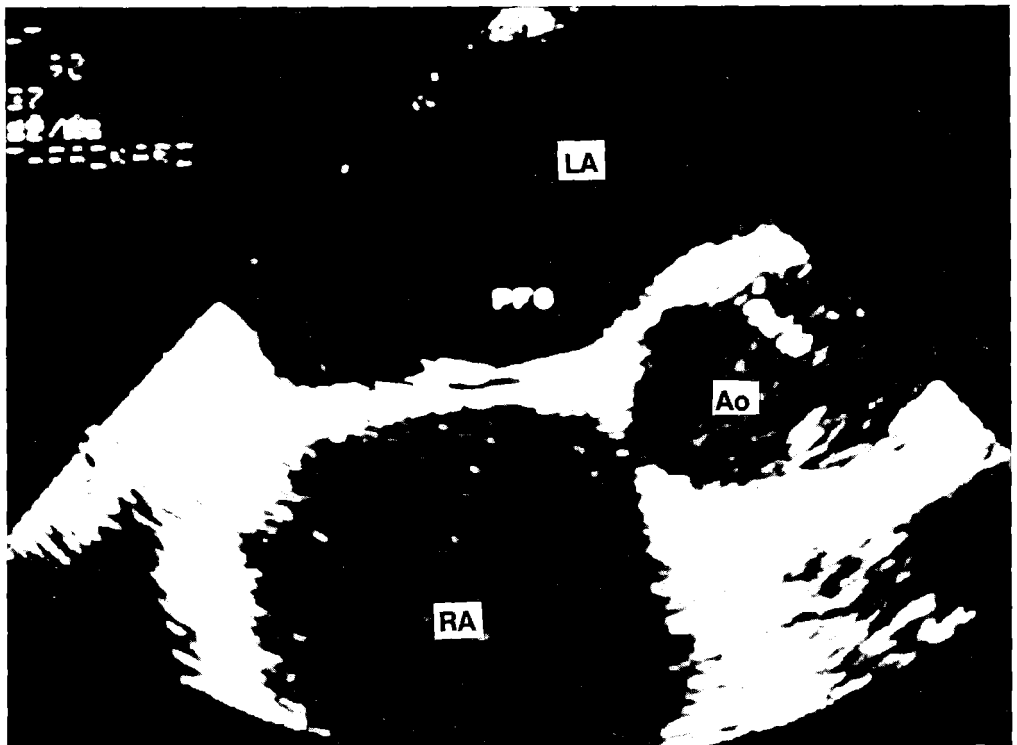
Documentation of a patent foramen ovale by transesophageal cross-sectional imaging. These are readily identified by their two-layered appearance and the evidence of blood flow contained within the space on subsequent color flow mapping studies.
